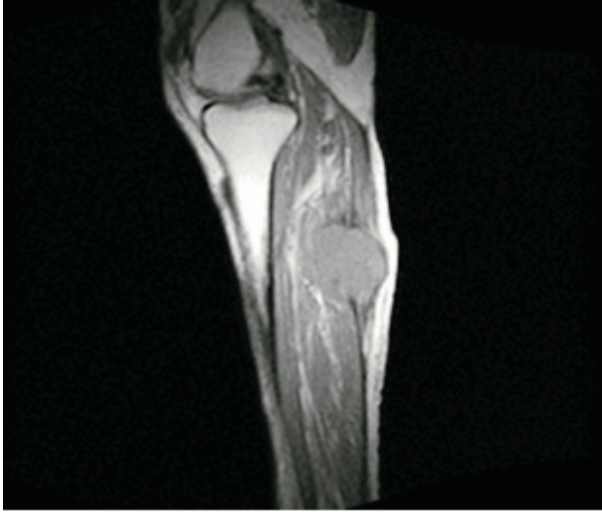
MR image of right cruris
